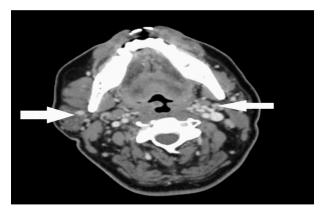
CT SCAN OF NECK: showing bilateral multi-level cervical lymph nodes (Arrows).
